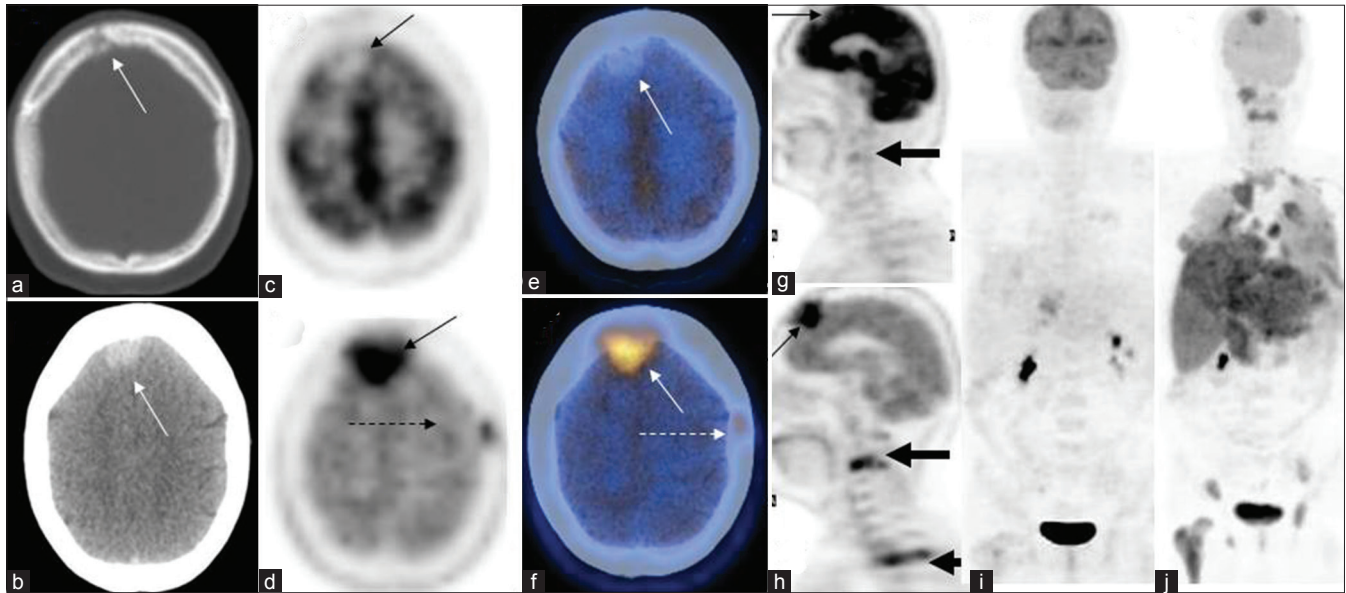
CT shows erosion in right frontal bone (bone window a) with an extra-axial mass (brain window b), with reduced FDG avidity on the axial FDG PET (c), PET/CT (e), and sagittal PET (g) image (thin arrows). Corresponding Met images show increased uptake (d,f,h), with additional calvarial sites of uptake (d,f-dotted arrows). Vertebral metastases with spinal canal extension noted on sagittal Met-PET image (h-thick arrows), whereas single lesion is seen on the FDG PET image (g). MIP image shows several additional sites of uptake on the Met scan (j) compared with the FDG scan (i). CT = Computed tomography, FDG = fluorodeoxyglucose, PET = Positron emission tomography, MIP = Maximum intensity projection
